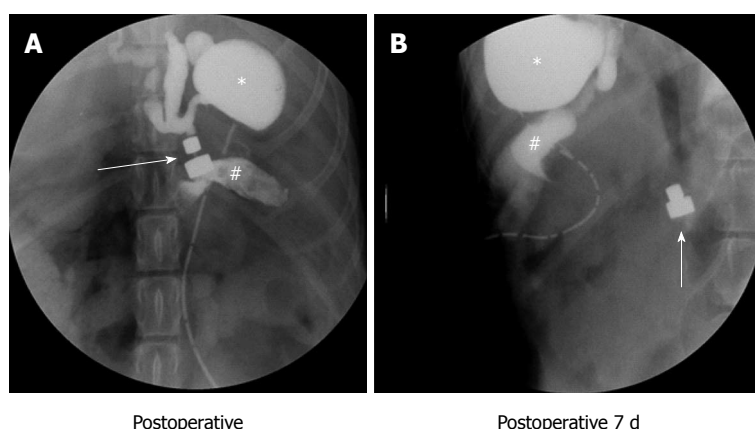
Postoperative abdominal X-ray. The path of the magnet pairs was monitored via an abdominal X-ray examination. The arrows indicates the magnetic pair, the asterisk indicates the gallbladder and the pound sign indicates the jejunum. A: Abdominal X-ray examination immediately after surgery; the two parts of the magnet pair coupled very well, exhibited good patency and were leak free; B: Daily abdominal radiography until the magnets were shed from the anastomosis.
